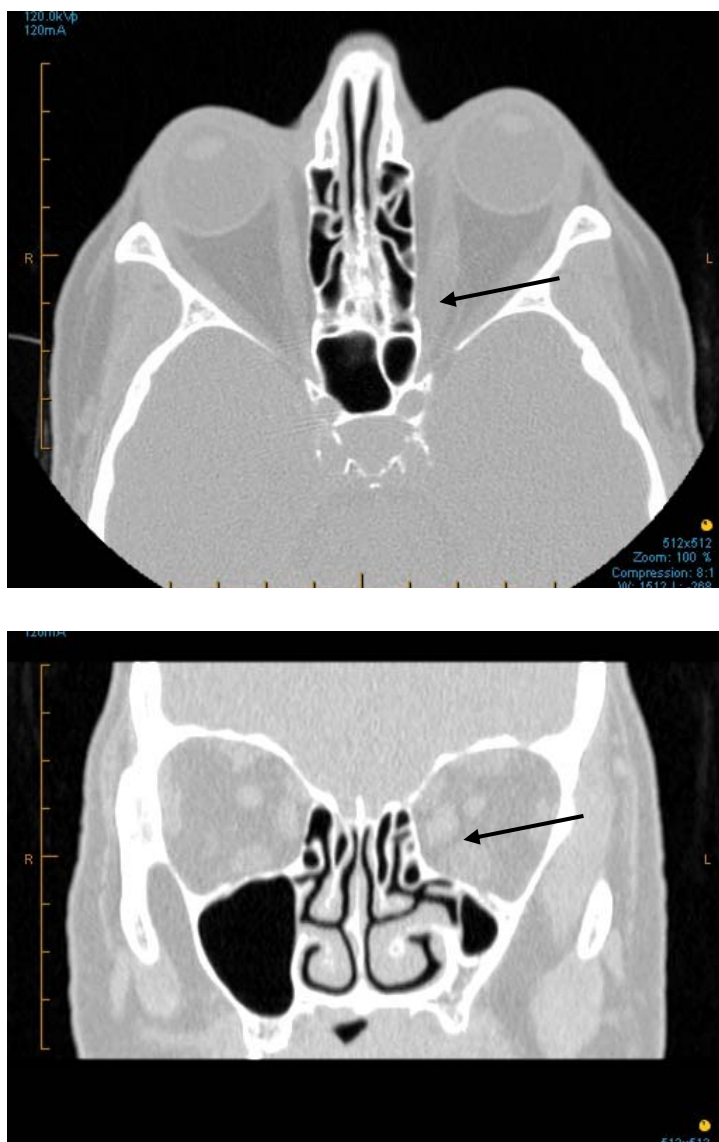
3 Axial (above) and coronal (below) CT images of a patient with GO showing enlarged extra-ocular muscles. Black arrow indicates enlarged medial rectus muscle.
